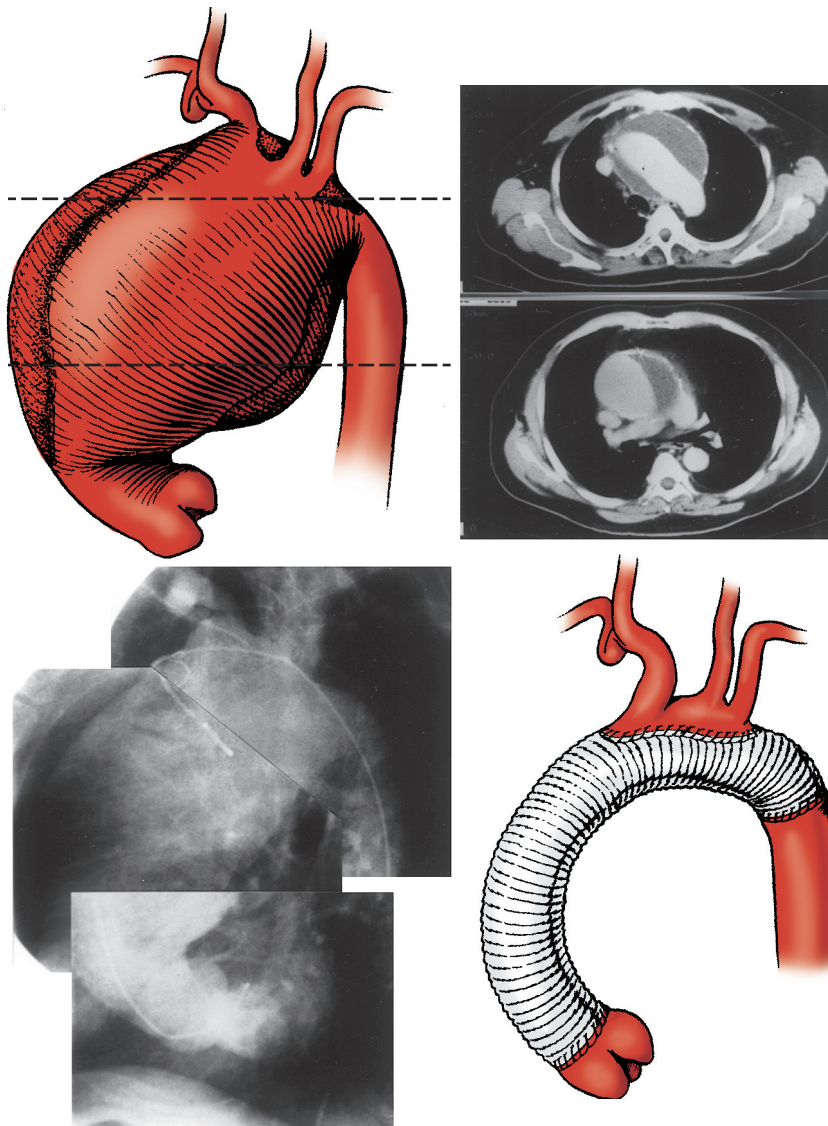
■ For this aneurysm involving only the ascending and aortic arch and proximal descending aorta, an elephant trunk procedure was not necessary. Note the extensive clot formation in the aneurysm shown on the computed tomography scan. The arch was repaired by sewing the graft into the proximal descending aorta and then reattaching the greater vessels as a Carrel patch.
